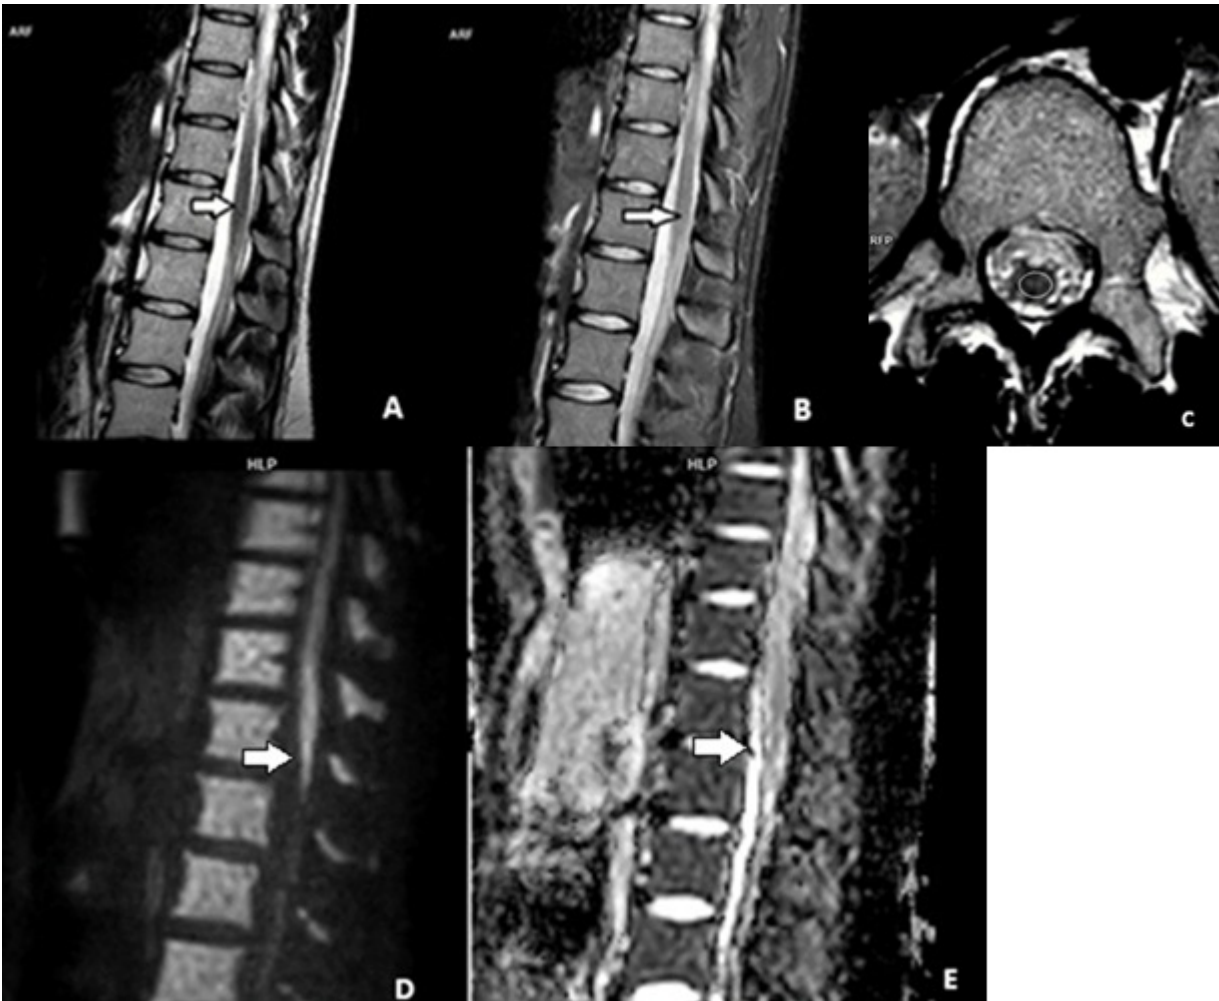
First follow up, ten days later. Sagittal STIR (A) and T2 (B) show subtle linear hyperintensities in the anterior-central part of conus medullaris/D11-D12, corresponding subtle and faded spot of restricted diffusion in sagittal DWI (C)/ADC (D) indicating very limited ischemic changes. Axial T2 TSE_one hyperintense spot in central conus medullaris D12/L1 (E) corresponding to central gray matter involvement. D11-D12 in left image (F), two central-anterior hyperintense spot resembling “owl-eyes” in the right image corresponding to anterior horns involvement.
